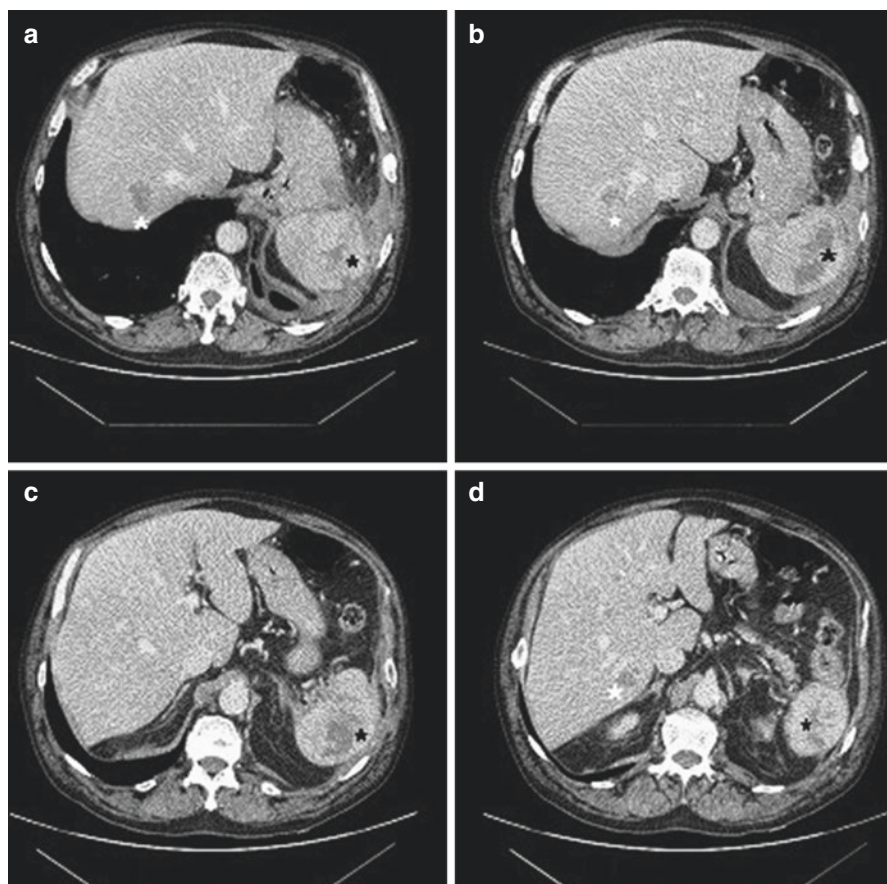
(a–d) Abdominal CT scan demonstrating liver (white stars) and spleen (black stars) aseptic abscesses
